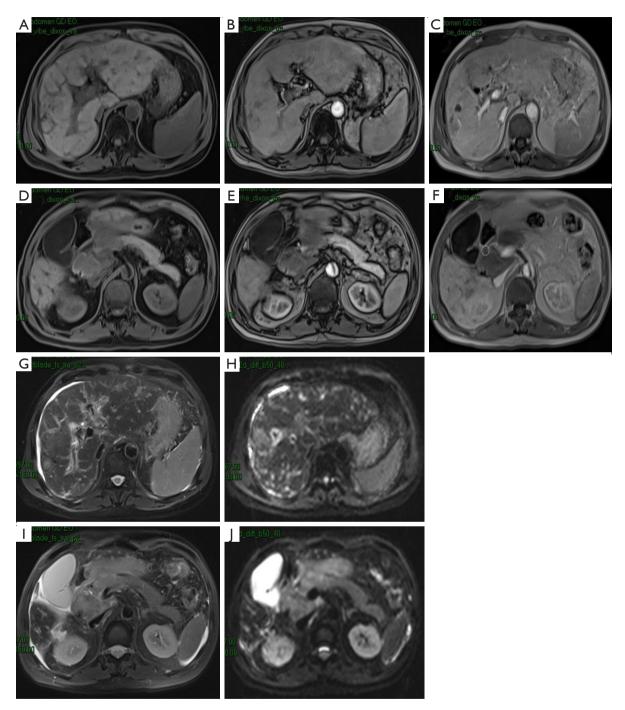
MR images after six courses of HAIC: (A,D) transverse T1-weighted imaging, contrast-enhanced dynamic T1-weighted imaging at the (B,E) arterial phase and (C,F) delayed phase, and (G,I) transverse T2-weighted and (H,J) transverse diffusion-weighted imaging. MR, magnetic resonance; HAIC, hepatic arterial infusion chemotherapy.
